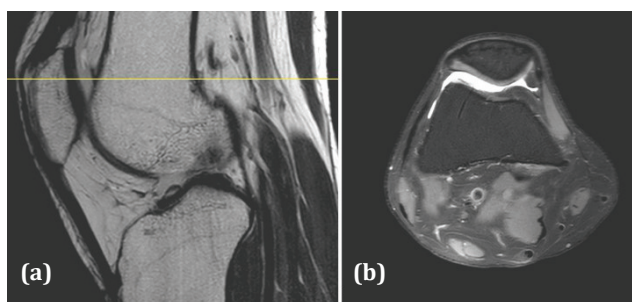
MRI on the right knee after 9 months of conservative treatment (a) T2 sagittal image and (b) axial proton density fat-saturated image wherein the focal subchondral edema found over the medial patellar facet has disappeared (Flip angle: 90°).
